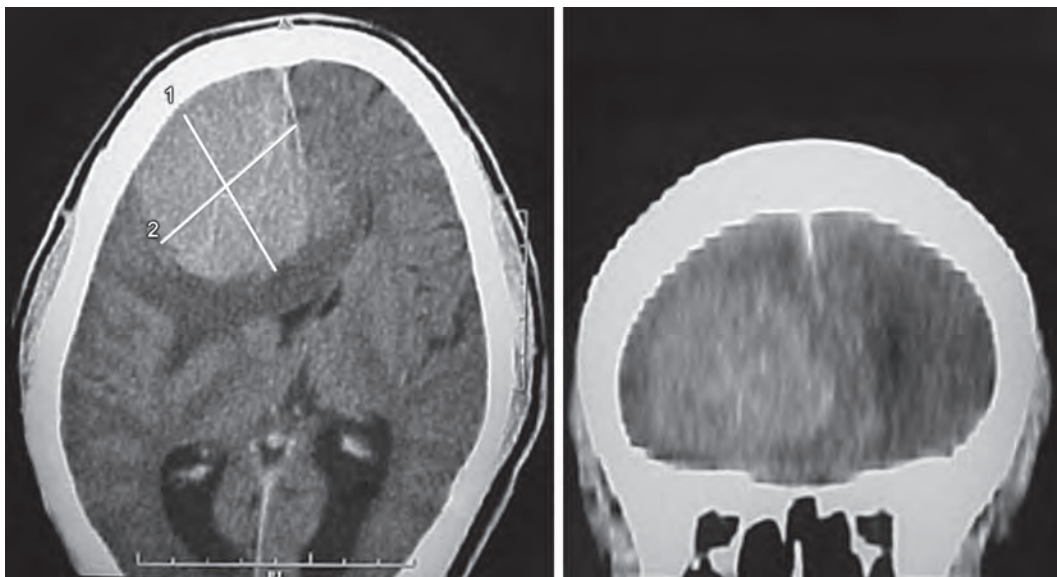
CT scan showing a large anterior-third falx meningioma
